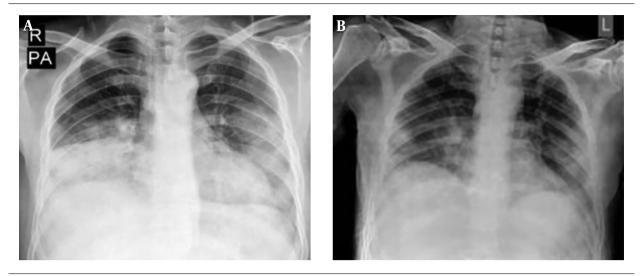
Comparison of chest radiography of the case 2: A, In the first; B, and last days of the treatment
